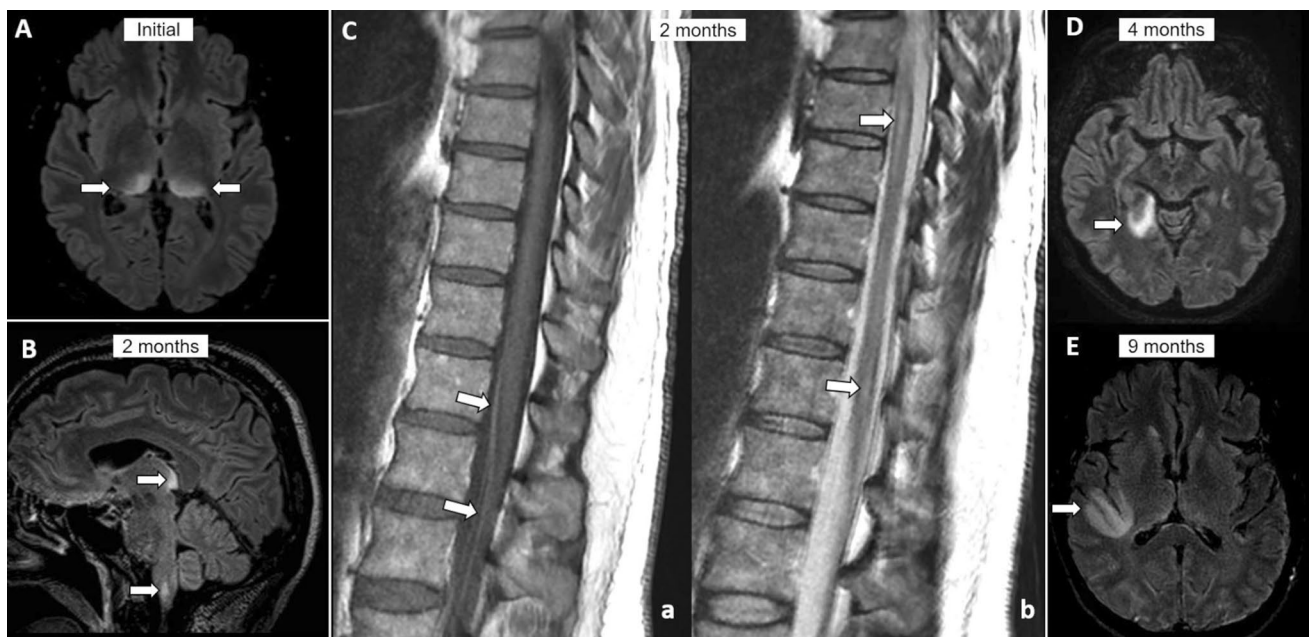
Neuroimaging evolution. On initial brain MR, 4 months after onset of the first symptoms, axial (a) post-contrast FLAIR views demonstrated bilateral hyperintensities of the pulvinar (arrows), the posterior area of the thalami. At 2 months, sagittal (b) post-contrast T2/FLAIR revealed an additional hyperintense focus in the left medulla oblongata (lower arrow) and unchanged hyperintense signal in the thalami (upper arrow). Sagittal contrast-enhanced T1-weighted
